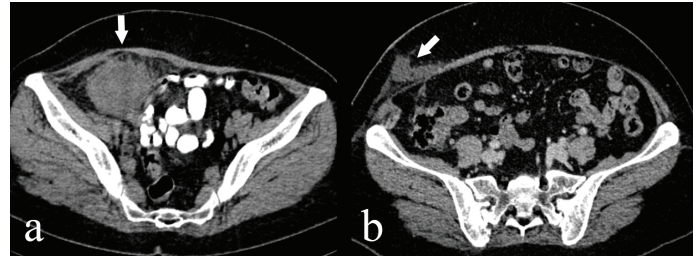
Abscess (arrow) in right lower quadrant on pre-interventional CT (a) and recurrent abscess formation (arrow) in catheter trace on post-interventional CT (b) 6 months after percutaneous drainage in 51-year-old woman with perforated appendicitis.
